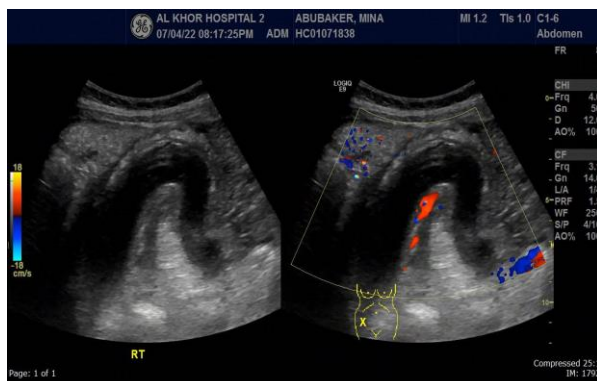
Ultrasound image showing right dilated ovarian vein
